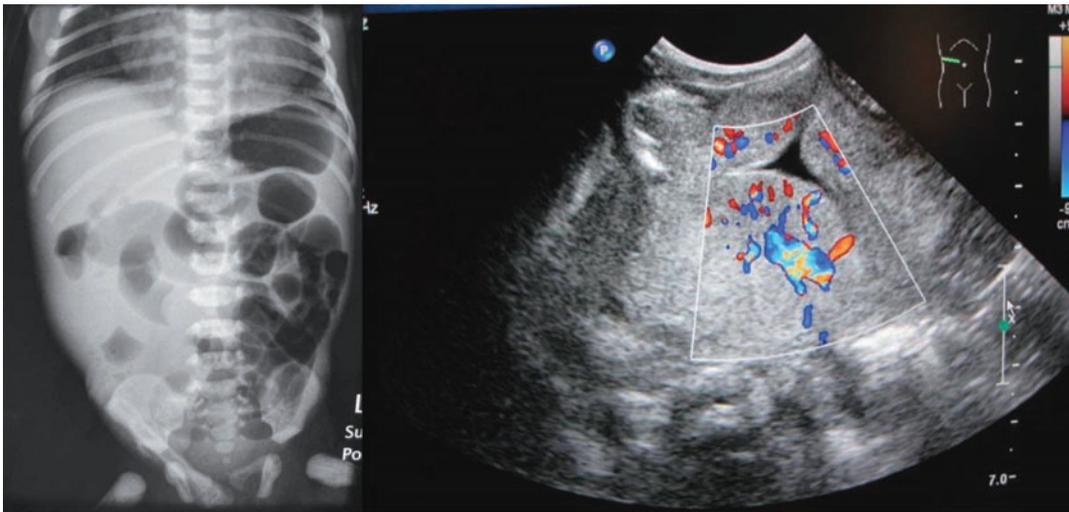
Pre-operative abdominal radiograph and sonogram suggesting a right sided abdominal mass of coiled intestine loops with compressed mesenteric vessels.
